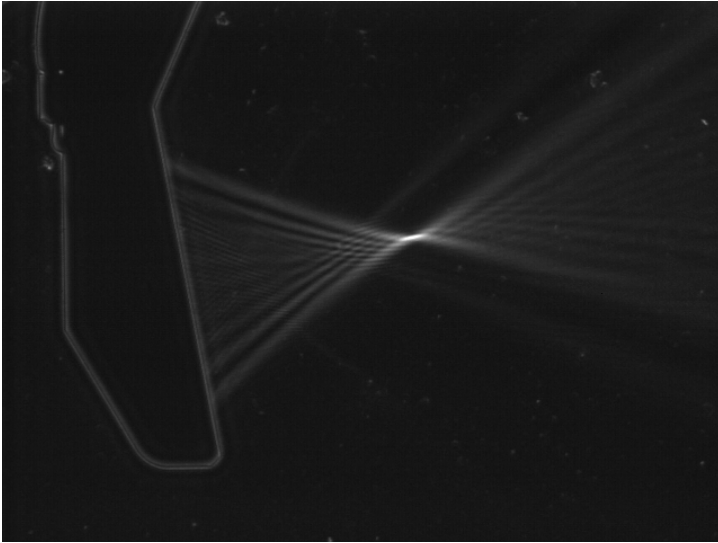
Focal ultrasonic field of the HIFU transducer at 3.2 MHz.
